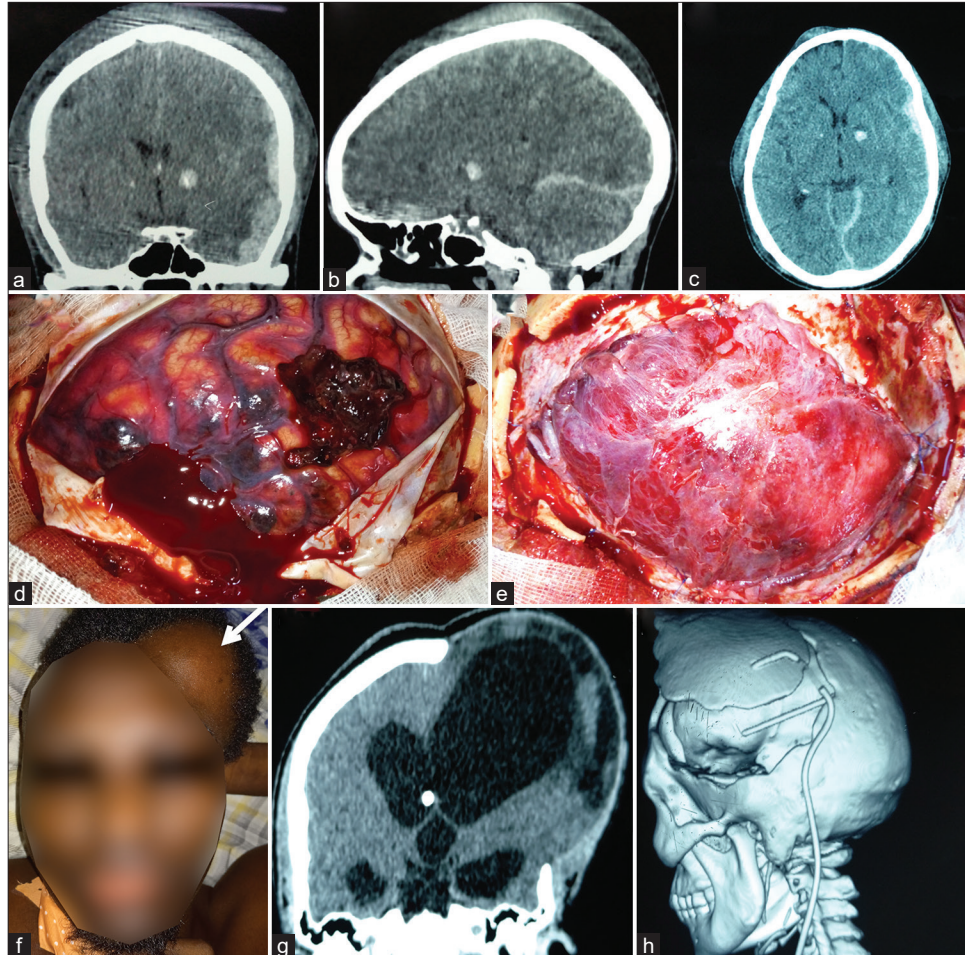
Iconograms of a 20-year-old patient who underwent decompressive craniectomy following a road traffic accident resulting in severe head trauma, the operative sequelae of which were complicated by major hydrocephalus. (a-c) Preoperative computed tomography images showing diencephalic contusions, acute subdural hematoma, and subarachnoid hemorrhage; (d and e) Intraoperative images showing cerebral contusions and duroplasty; (f) Late postoperative frontal photograph showing distension opposite the cranial flap (white arrows); (g and h) Postoperative control computed tomography images showing tetraentricular hydrocephalus with disconnection of the ventriculoperitoneal shunt.
